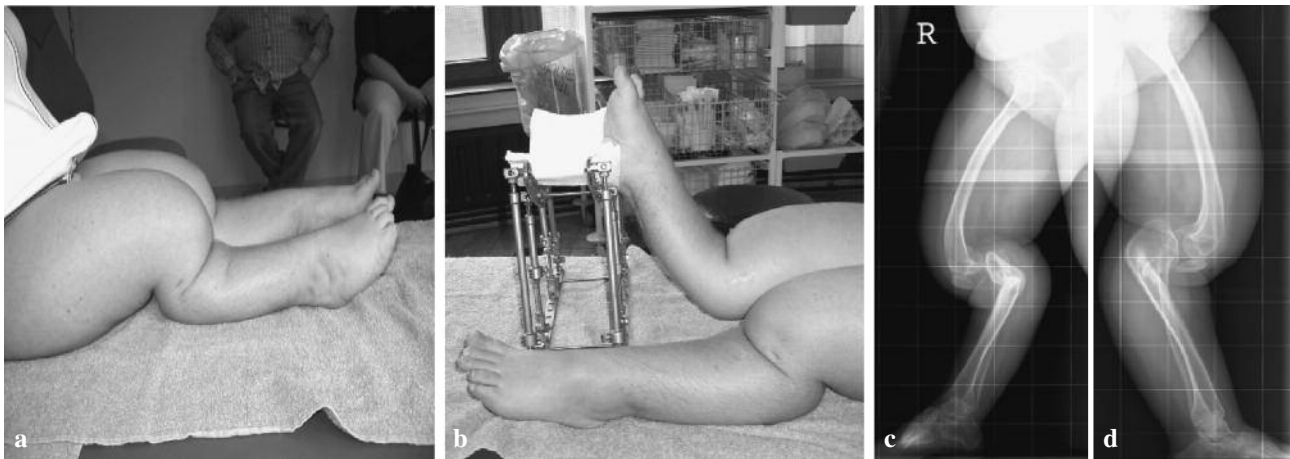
A, B. Clinical presentation of a pseudoachondroplasia patient with extreme bilateral genu recurvatum. When bending the knees, the legs appear straight (a). True recurvatum becomes apparent when the knee joint is fully extended (b). c, d. Lateral full leg radiographs of both legs showing hip dysplasia, femoral bowing, aberrant sagittal tilting of the condyles and an abnormal tibial slope. With legs apparently straightened, there is an almost vertical joint line.
